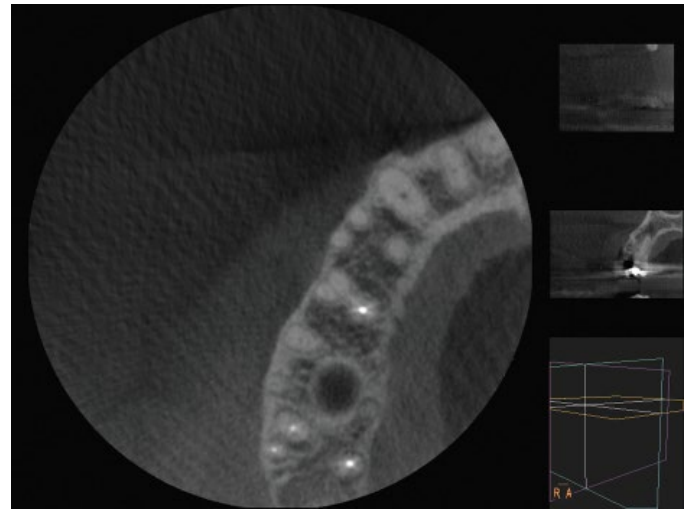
(D) CBCT axial plane image shows two untreated buccal canals. Reproduced with permission of Dr J. Chikvashvili.
